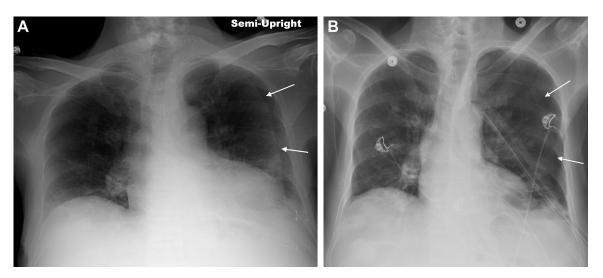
A, Portable anterior-posterior chest radiograph in a 69-y-old man with chest pain demonstrating a skinfold with no visceral pleural edge projecting over the lateral left hemithorax (arrows). The finding was misinterpreted as a left pneumothorax and prompted chest tube placement. B, Follow-up portable AP chest radiograph in the same patient after chest tube placement resulting in a new iatrogenic left pneumothorax with thin opaque visceral pleural edge now visible (arrows).
